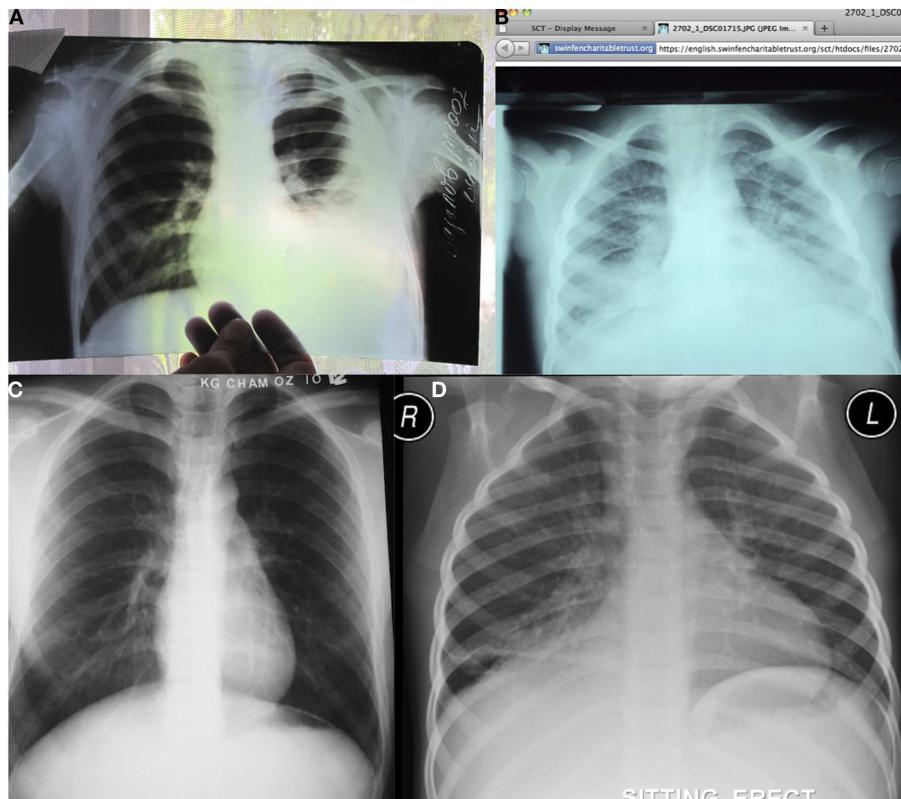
A variety of pediatric teleradiology referrals. (A) An X-ray referral from an MSF site in Tajikistan was received as a JPEG created by holding the hard copy X-ray up against a window and photographing it digitally. The curtains on the backdrop are seen through portions of the radiograph as a fine checker pattern. Although this was an inadequate X-ray referral the left-sided effusion is clearly visible. (B) Pediatric X-ray referral from the Collegium Telemecum platform for MSF. The radiograph is of relatively poor quality as it is underinspired and the patient is markedly rotated to the left. In addition, the image has not been converted to gray scale. The right middle lobe air-space disease is visible but difficult to distinguish from density at the bases probably the result of poor inspiration. It is also difficult to comment on the presence of lymphadenopathy due to
